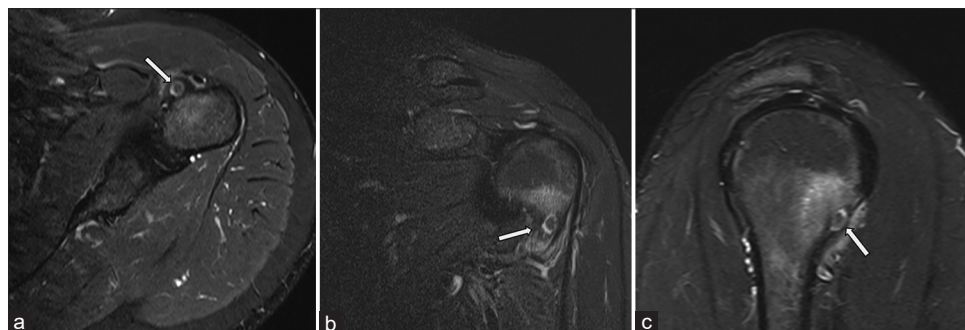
(a) Axial T2 fat saturated, (b) Coronal T2 fat saturated, and (c) Sagittal T2 fat saturated MRI of the right shoulder demonstrate a small 7-mm rounded intracortical lesion within the proximal humeral shaft anteriorly (arrows) demonstrating heterogenous signal intensity. The center of the lesion appears hypointense within thin hyperintense margin. This is associated with surrounding reactive bone marrow edema. MRI – Magnetic resonance imaging
